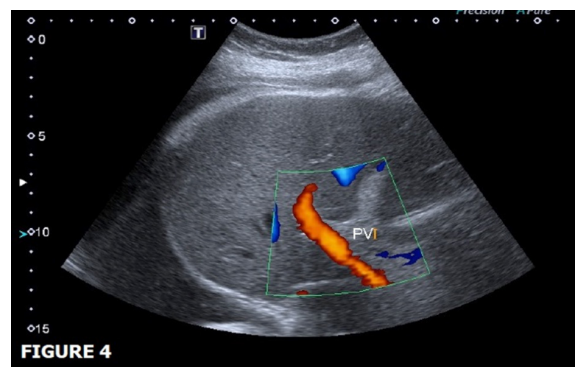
Doppler ultrasound scan of the portal vein shows normal patency of the portal vein.
